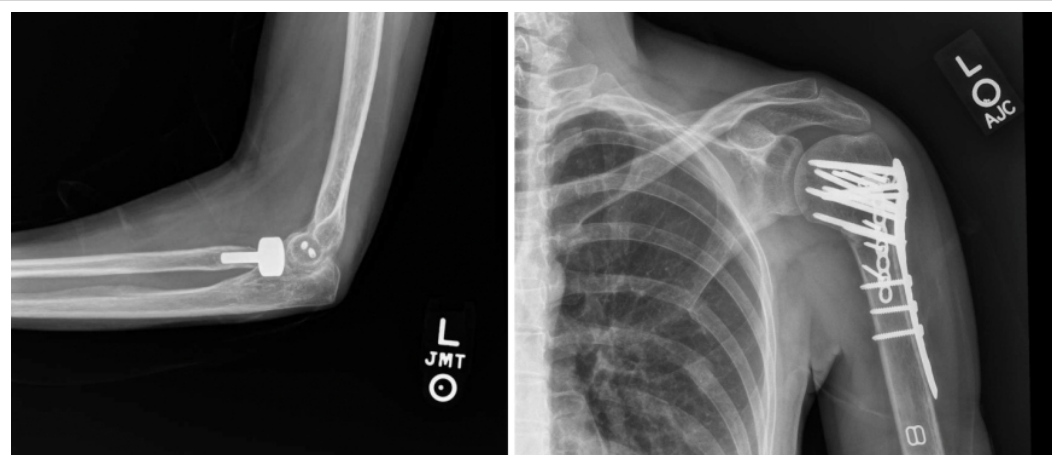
Post-operative lateral left elbow (left) and anteroposterior left shoulder (right) X-rays.
